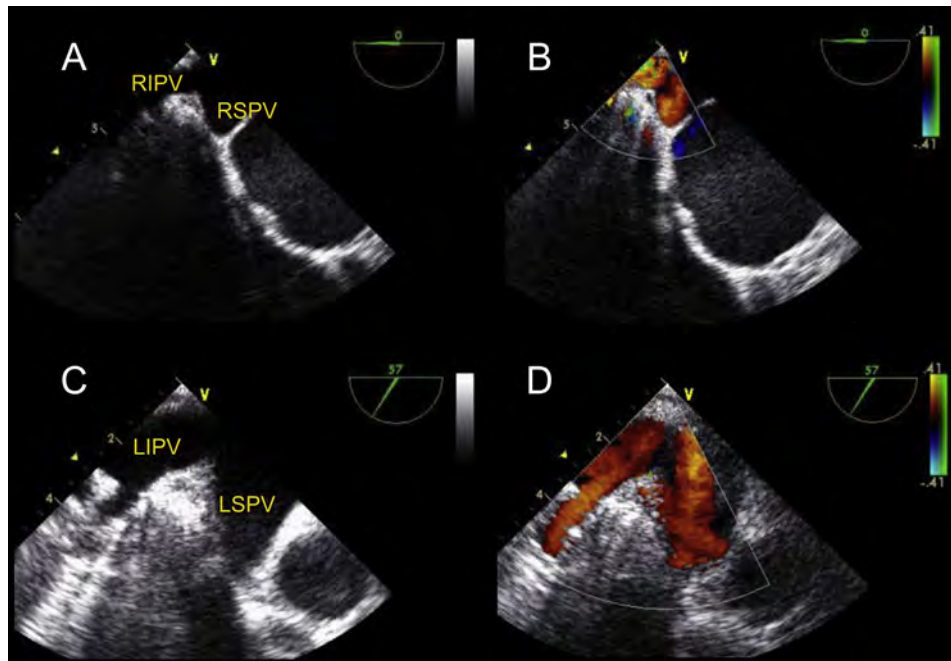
TEE demonstrating from the upper esophageal short-axis view demonstrating the right pulmonary veins at (A) 0° without and (B) with color Doppler and (C) without and (D) with color Doppler at 60°. LIPV, left inferior pulmonary vein; LSPV, left superior pulmonary vein; RIPV, right inferior pulmonary vein; RSPV, right superior pulmonary vein.
